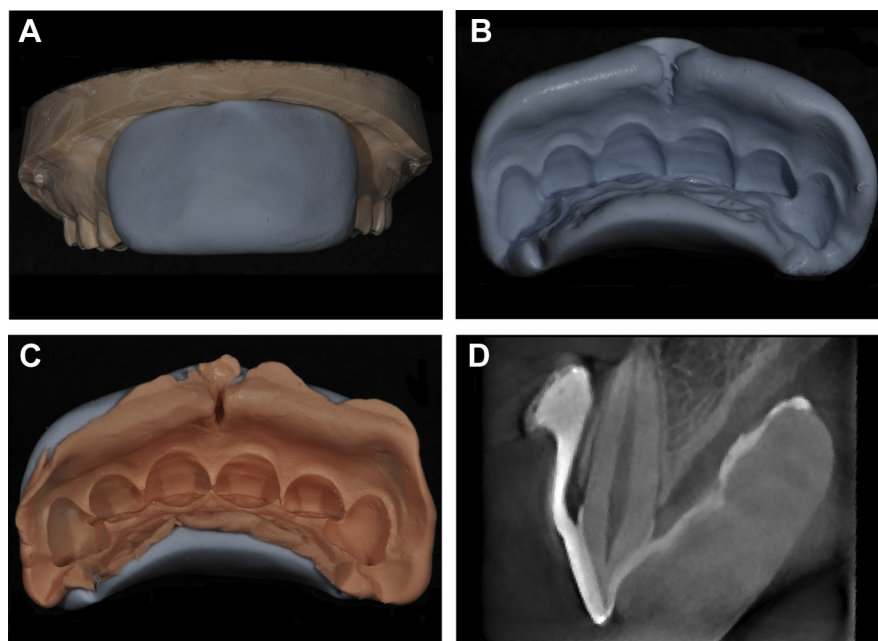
Fabrication procedures. A, Silicone matrix was fabricated on the cast. B, Silicone matrix before relief space preparation. C, Final wash impression using silicone matrix with mixed opaque agent and alginate material. D, Reconstructed cone beam computed tomography image showing sagittal section of dentogingival profile of the upper right central incisor.
